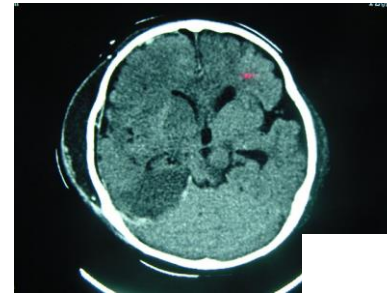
Epidural hematoma (EH) from a short fall. A, CT of a large right EH with severe mass effect. B, A lateral skull parietal skull fracture (arrow).
